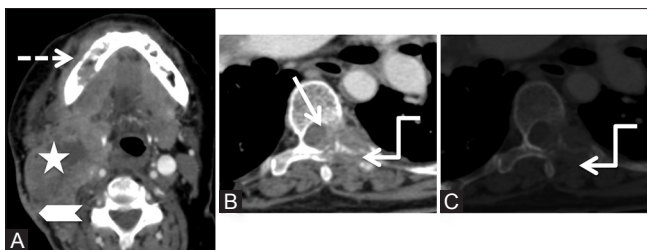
(A-C): Metastases: Post-contrast axial computed tomography scan images at the level of base tongue (A) and lower dorsal spine in soft tissue (B) and bone windows (C), in a 60-year-old female with previous right hemiglossectomy and nodal dissection, show a large heterogeneously enhancing recurrent mass (star) in the right side of the neck extending from submandibular region to posterior triangle. Note the involvement of sternomastoid muscle and overlying skin of the neck (arrowhead). Erosion of the right lower alveolus is also seen (dashed arrow). Lytic lesion is seen in the left transverse process and costovertebral joint (elbow arrow) with posterior epidural soft tissue (arrow) compressing the cord in lower dorsal vertebra
